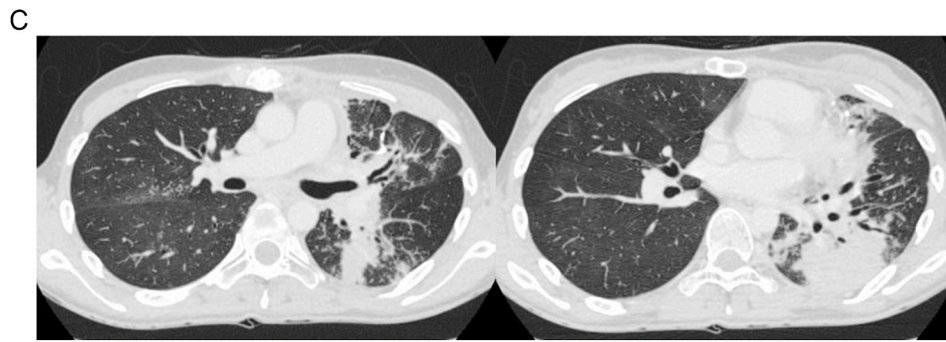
Chest computed tomographic images upon hospitalization. Chest computed tomography revealed centrilobular granular and infiltrative shadows and thickening of the bronchial wall in bilateral lung fields.
